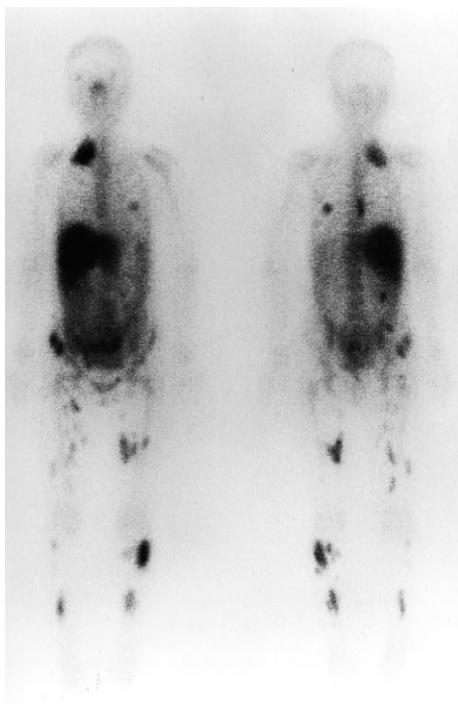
Whole-body Ga-67 scintigrams (*left*, anterior image; *right*, posterior image) demonstrate multiple sites of increased accumulation including the right lower neck and bilateral lower extremities.
